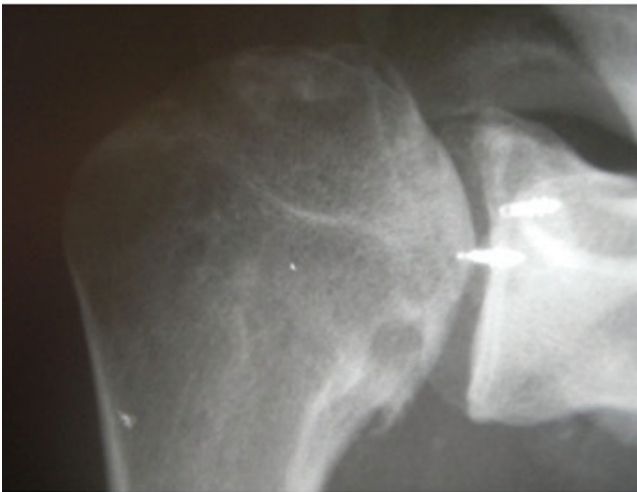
Radiograph in true AP view on the right shoulder. Postoperative control demonstration complete resection of the lower osteophyte of the humeral head and preservation of the joint space.
